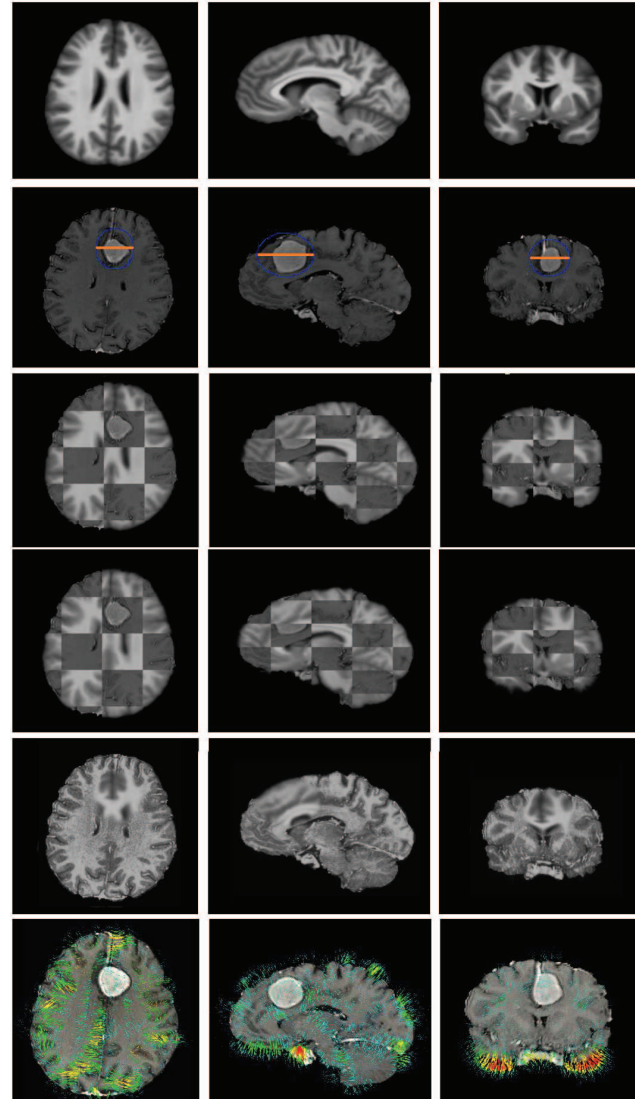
Register a brain template to the MRI of a meningioma patient.
